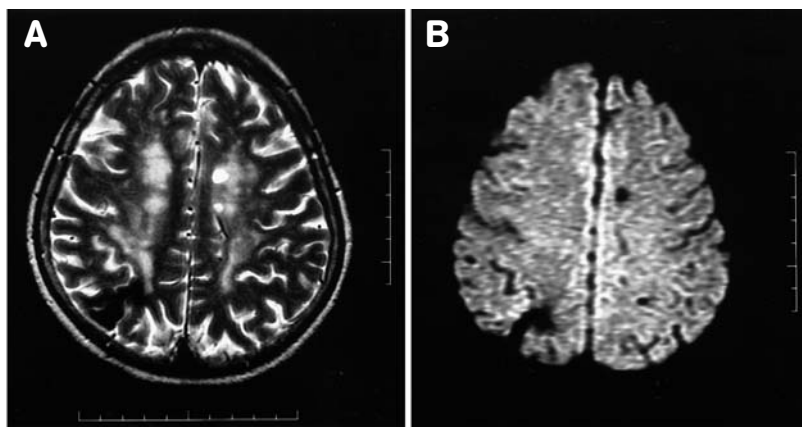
(A) T2-weighted brain MRI image showing a lesion in the right occipital area and (B) diffusion scan image showing no acute lesion in the corresponding area.
